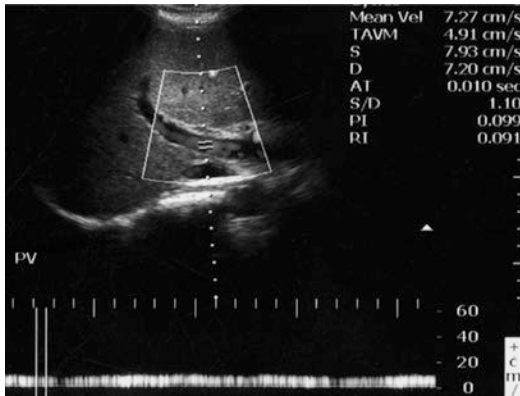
Normal portal vein Doppler waveform
